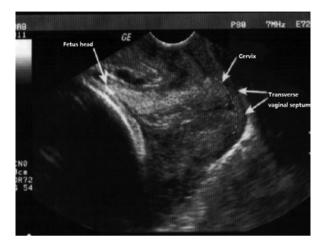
Ultrasound scan finding of a transverse vaginal septum during pregnancy
